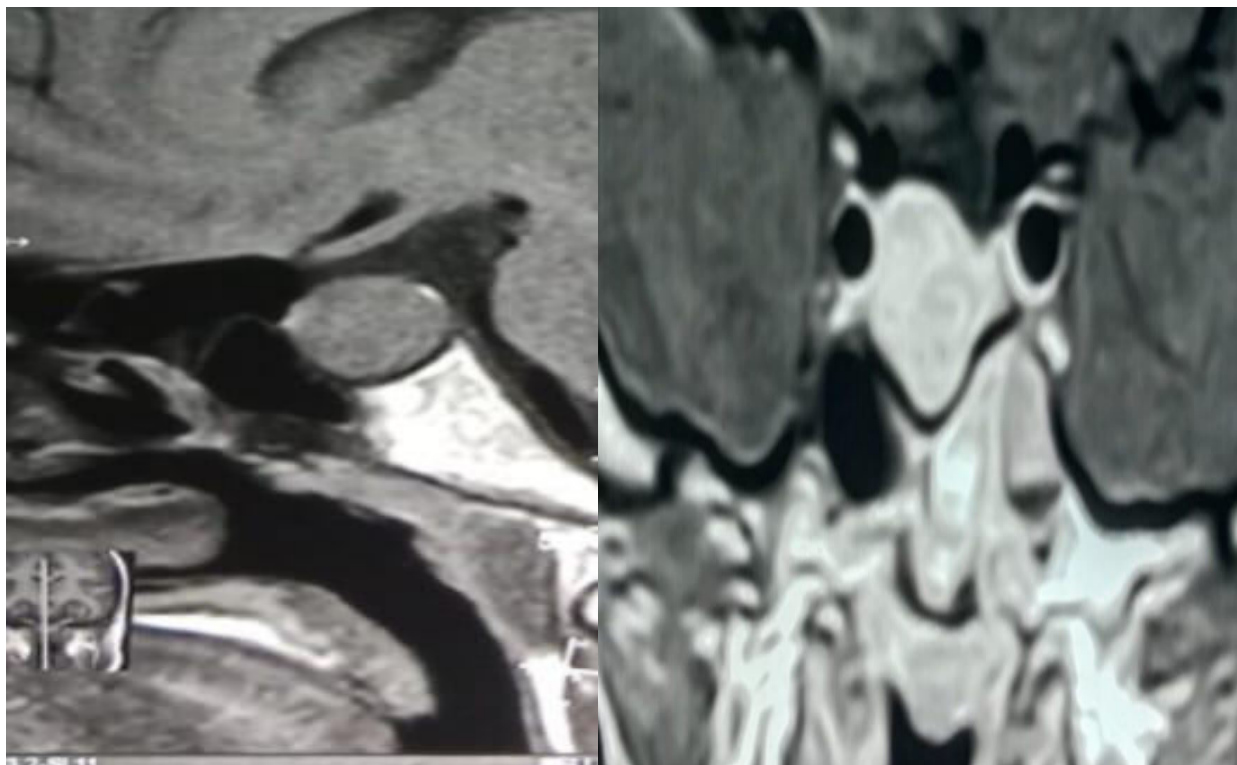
MRI T1 sagittal and coronal views post contrast enhancement preoperative recurrent pituitary macroadenoma reveals sellar and suprasellar extension with post contrast heterogenous enhancement.
